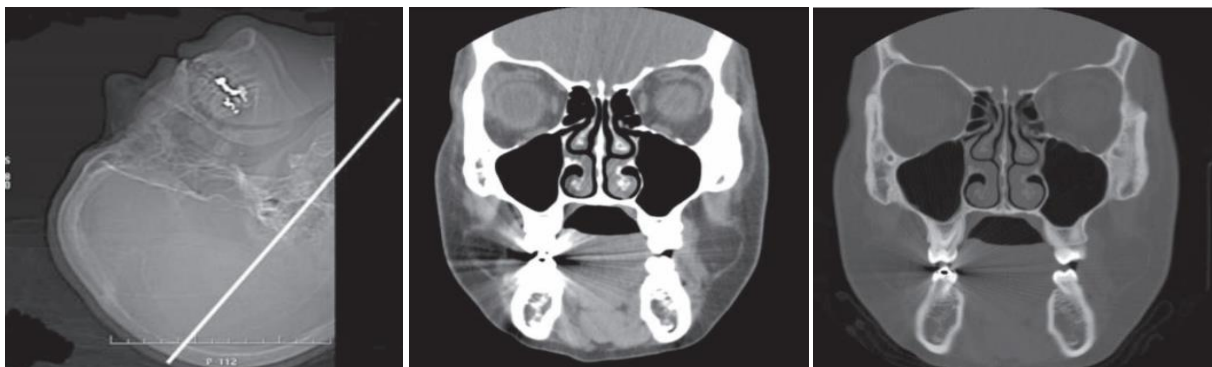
shows the coronal supine CT scan
